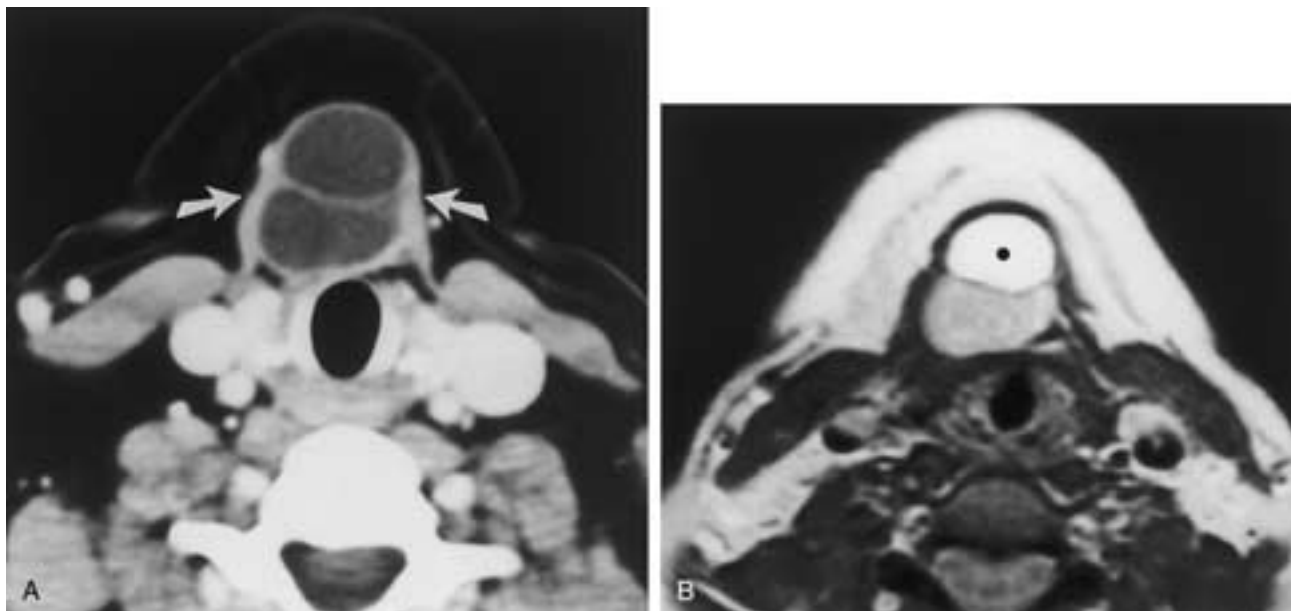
Papillary carcinoma in an infrahyoid thyroglossal duct cyst. A, Axial CT scan demonstrates a septated midline infrahyoid thyroglossal duct cyst lying deep to the infrahyoid strap muscles (arrows). B, Axial proton density (intermediate) MR image demonstrates high signal intensity fluid within the anterior compartment (dot) but heterogeneous solid tissue within the posterior compartment.
